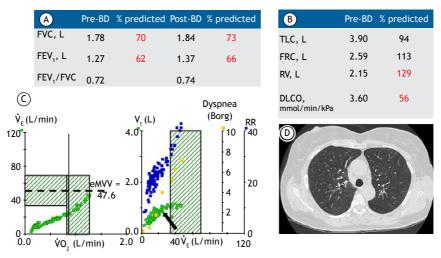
Physiological and structural investigations in a 59-year-old, former heavy smoker woman with complaints of chronic dyspnea. There was a proportional reduction in FEV, and FVC, leading to a preserved pre- and post-bronchodilator FEV₁/FVC ratio (in A), increased RV and reduced DLCO (in B), mechanical ventilatory limitation to exercise (in C; see text for further elaboration), and emphysema plus thickened airway walls on a chest CT (in D) that jointly indicate the presence of COPD. BD: bronchodilator; FRC: functional residual capacity; eMVV: estimated maximal voluntary ventilation; v_e: minute ventilation; $\dot{v}O_2$: oxygen uptake; and V_T : tidal volume.
